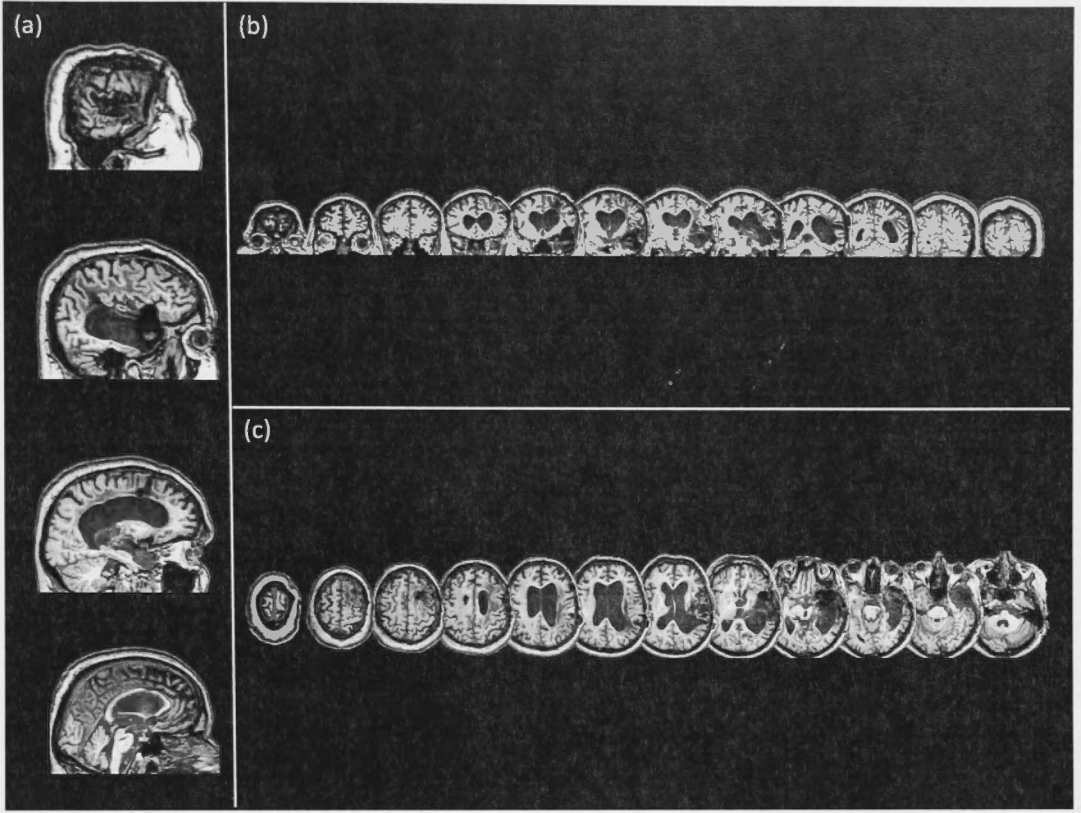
T1-weighted brain MR images of patient HT:
